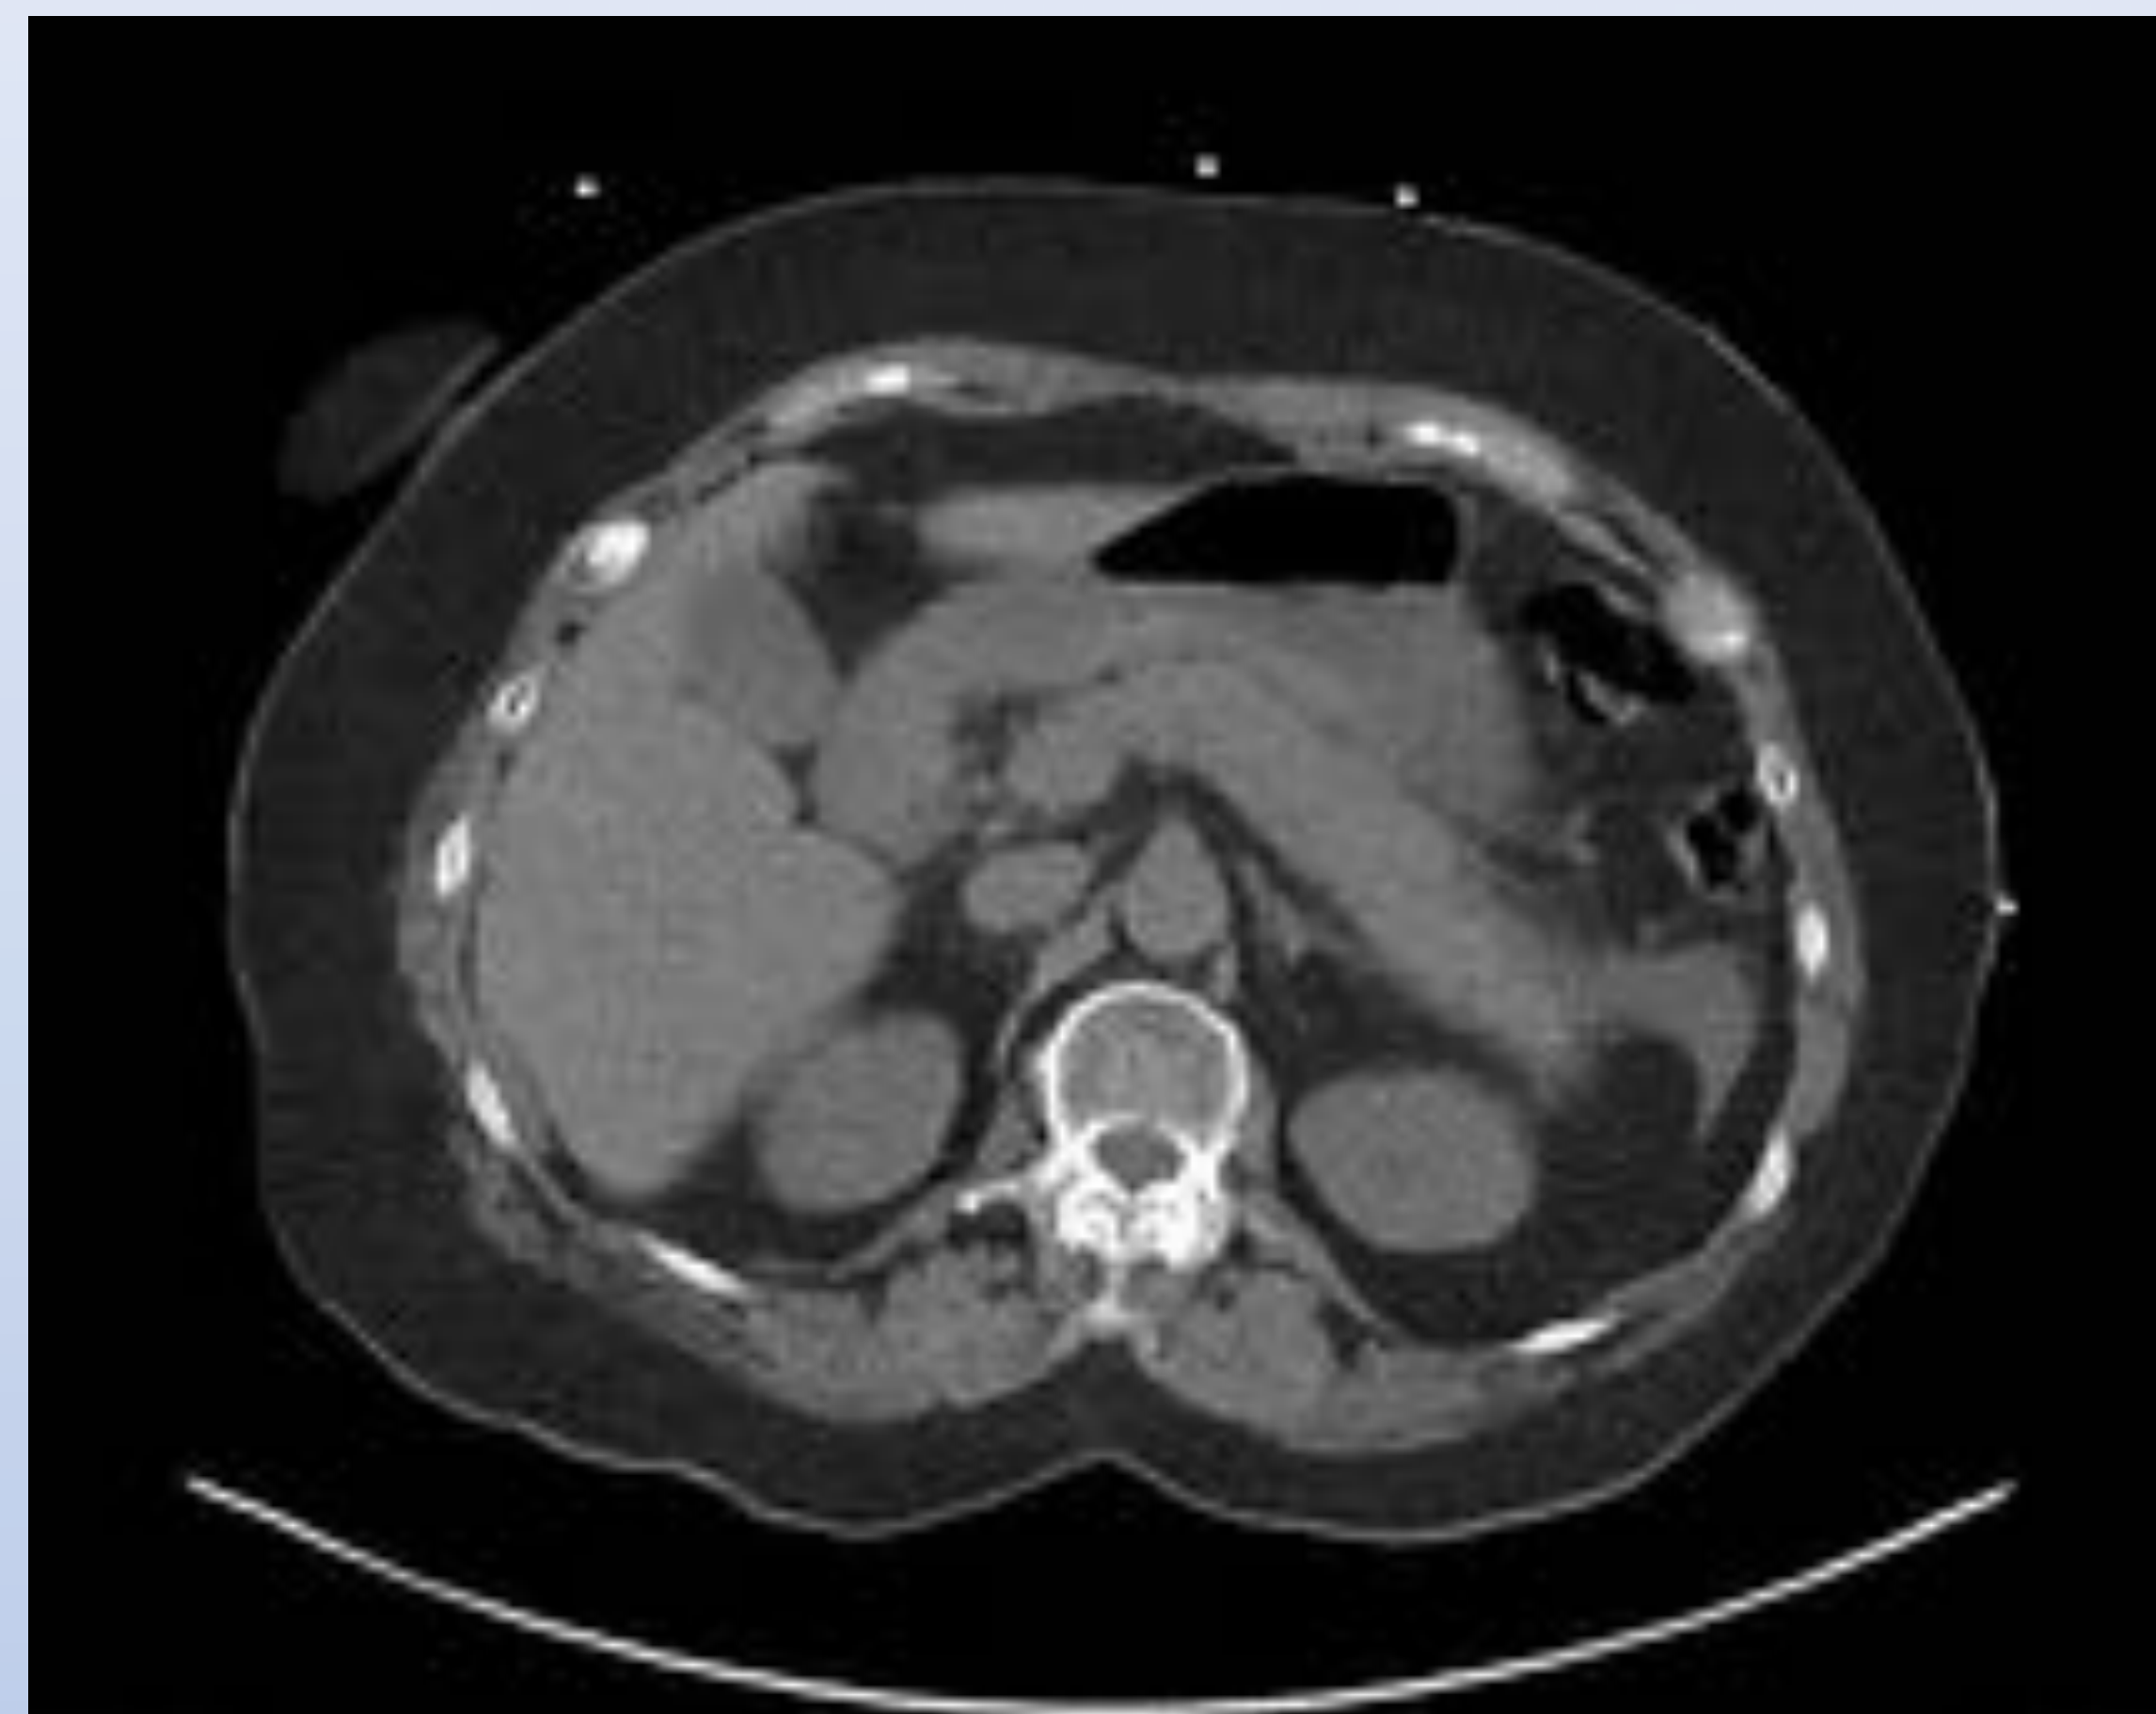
Axial CT scan of the abdomen revealing haziness along the body and tail of the pancreas as well as fluid at the left paracolic gutter consistent with acute pancreatitis.
